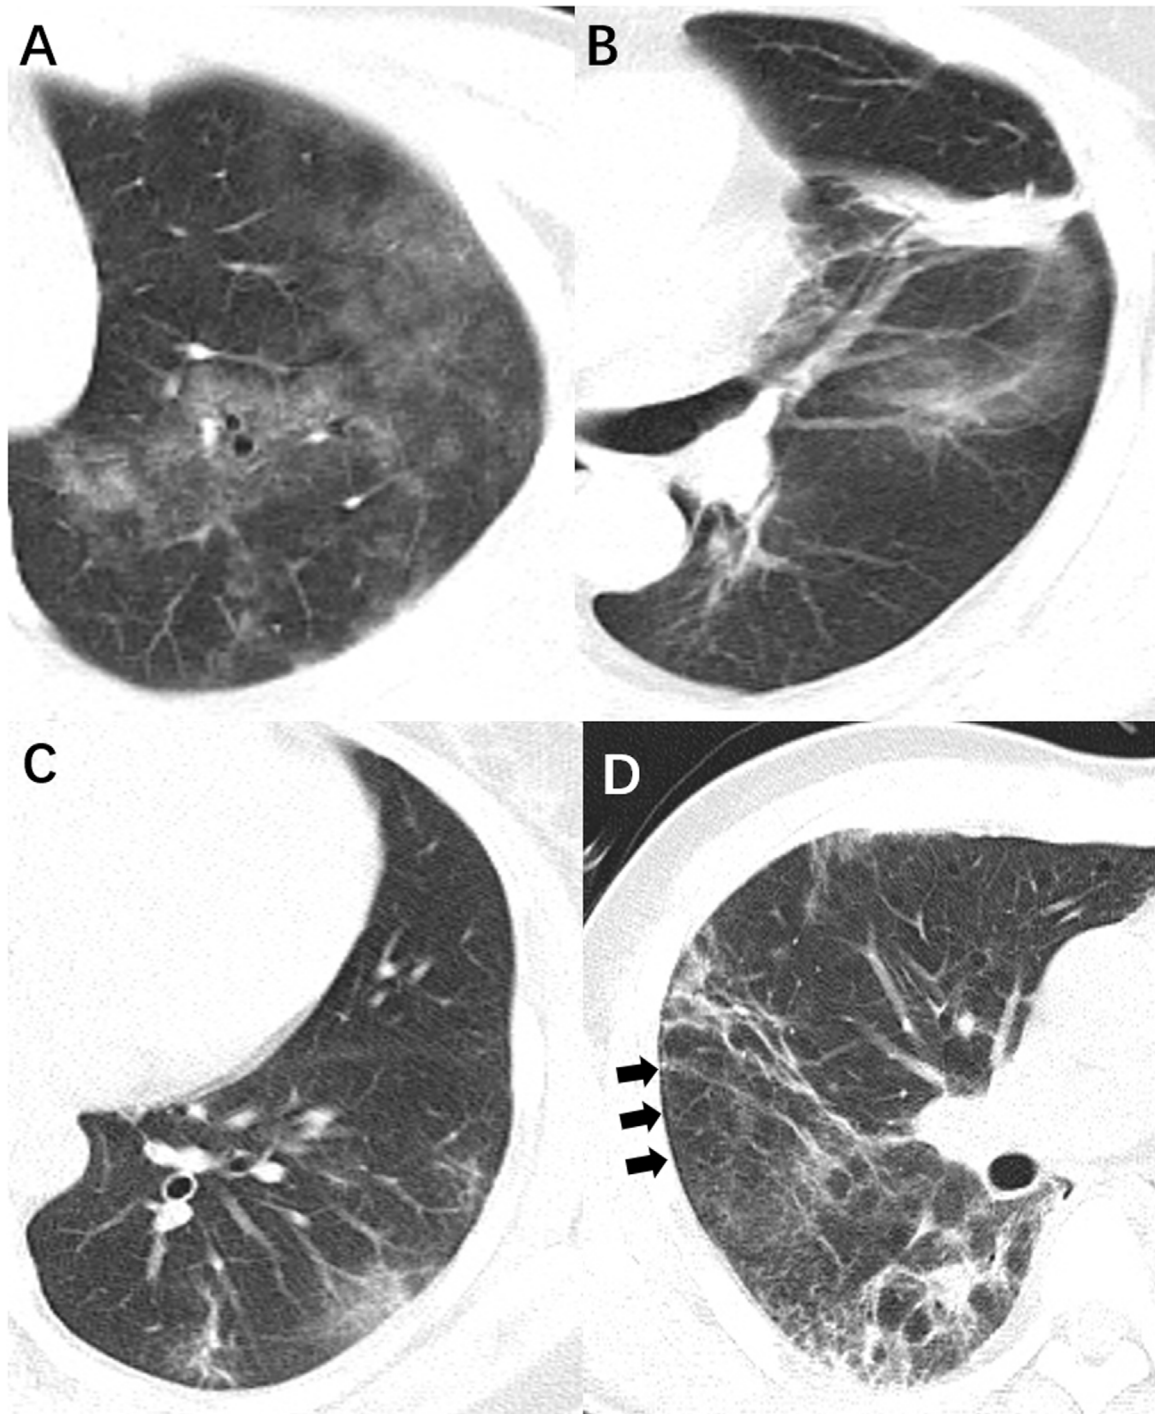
CT features in patients with co-infection of SARS-CoV-2 and HIV.
